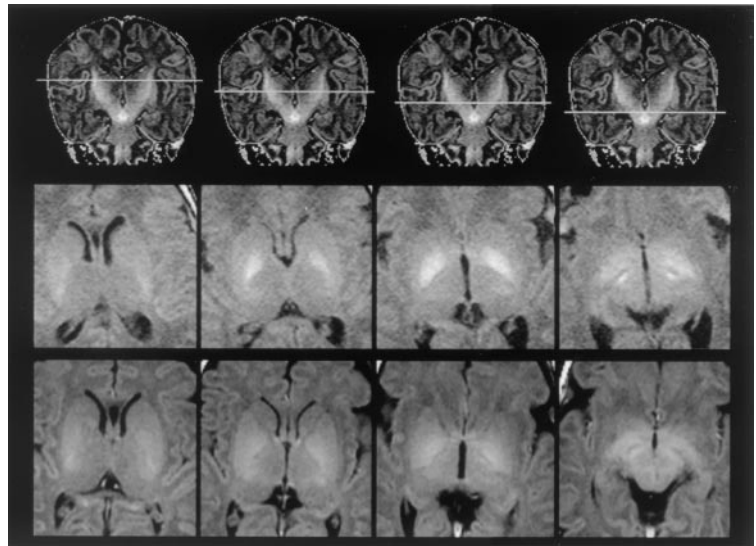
Axial IR-TSE T1-weighted MR on day 6 in patient 7: very high signal in entire globus pallidus on T1, mildly hyperintense aspect on T2 making pallidum just discernible from putamen.
